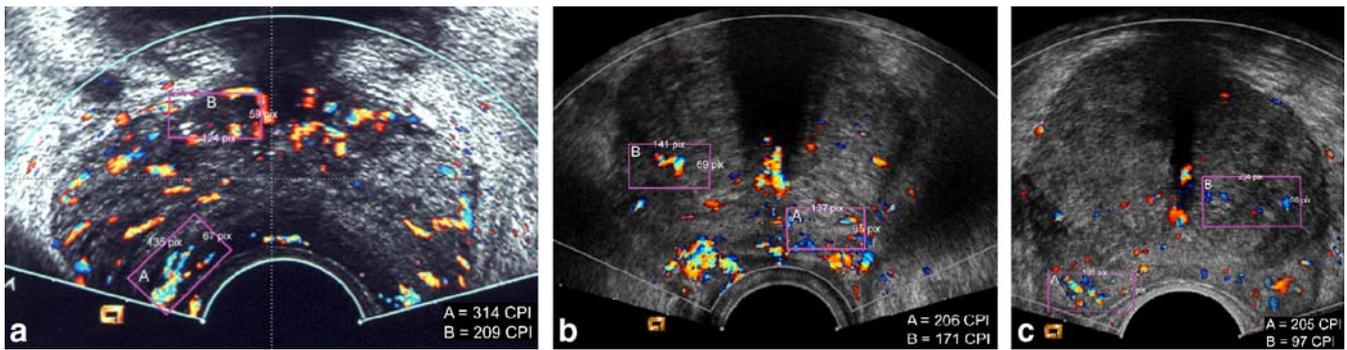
Measurement of CPI: contrast-enhanced colour Doppler ultrasound images showing the defined *rectangles* around the regions of interest (20 mm^2) in a non-diabetic patient with normal prostate (21 cm^3 , upper panel), a non-diabetic patient with BPH (74 cm^3 , middle panel) and a diabetic patient with BPH (81 cm^3 , lower panel)
